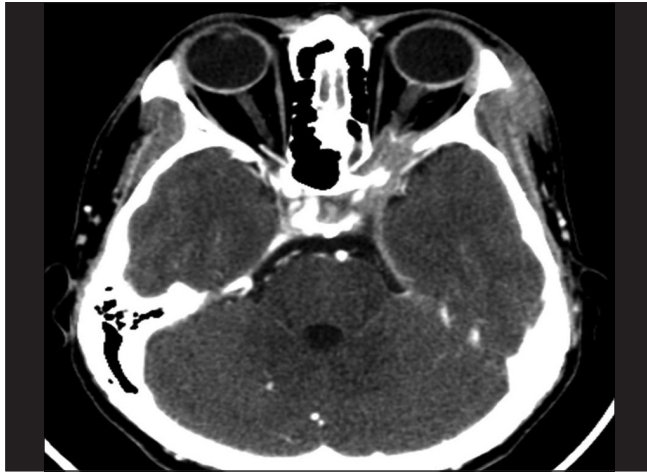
Computed tomography scan showing compression of the left optic nerve
